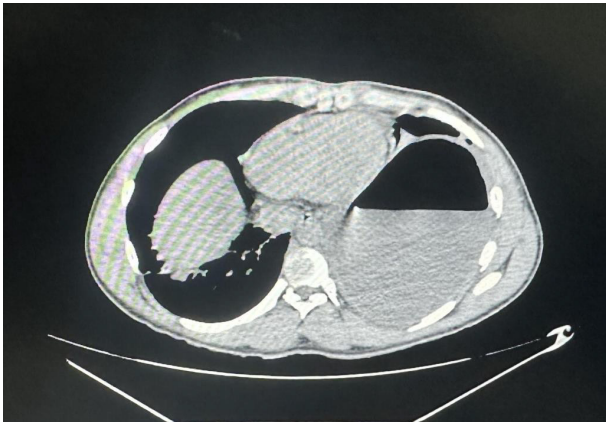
CT thorax showing the intrathoracic cystic cavity.
